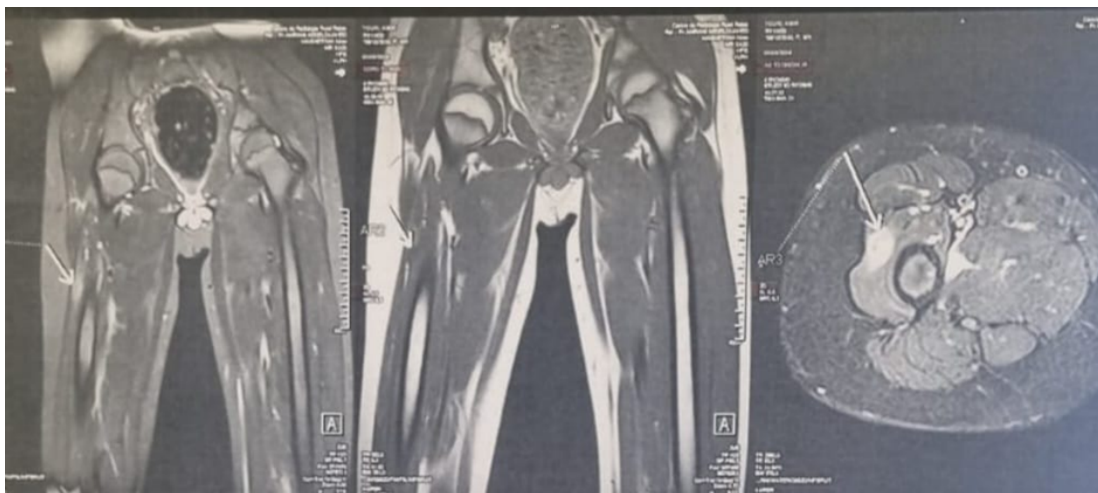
MRI picture showing a well-circumscribed small oval-shaped lesion at the lateral aspect of vastus lateralis in the right thigh.
